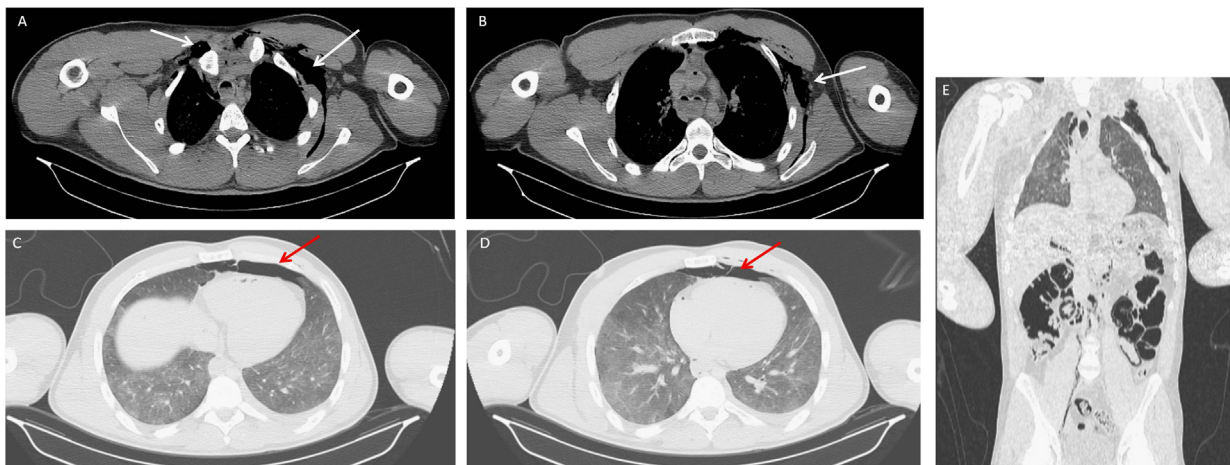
(a, b, c and d) Axial computed tomography (CT) scans: bilateral pneumothorax (red arrows) and subcutaneous emphysema (white arrows). (e) Coronal CT scan: a different view of the subcutaneous emphysema.
